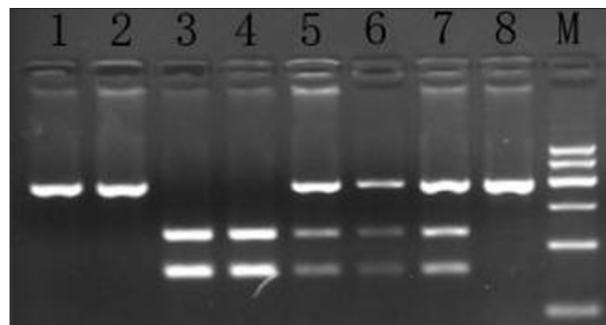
The *ABCC2* gene rs717620 polymorphism in PCR-RFLP electrophoresis map. M – Marker; 1, 2, 4, 5, 6, 7 – CC; 8 – CT; 3 – TT.
